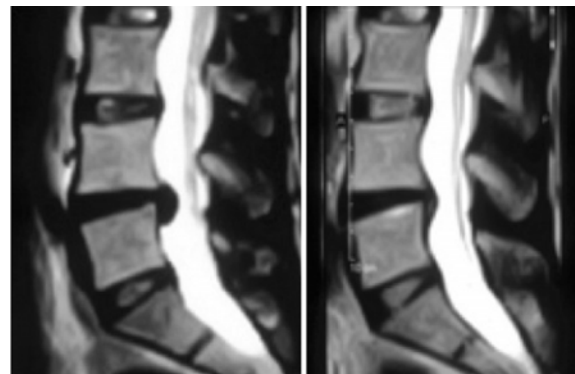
MRI Pre-Nucleoplasty and Post-Nucleoplasty 3 months
